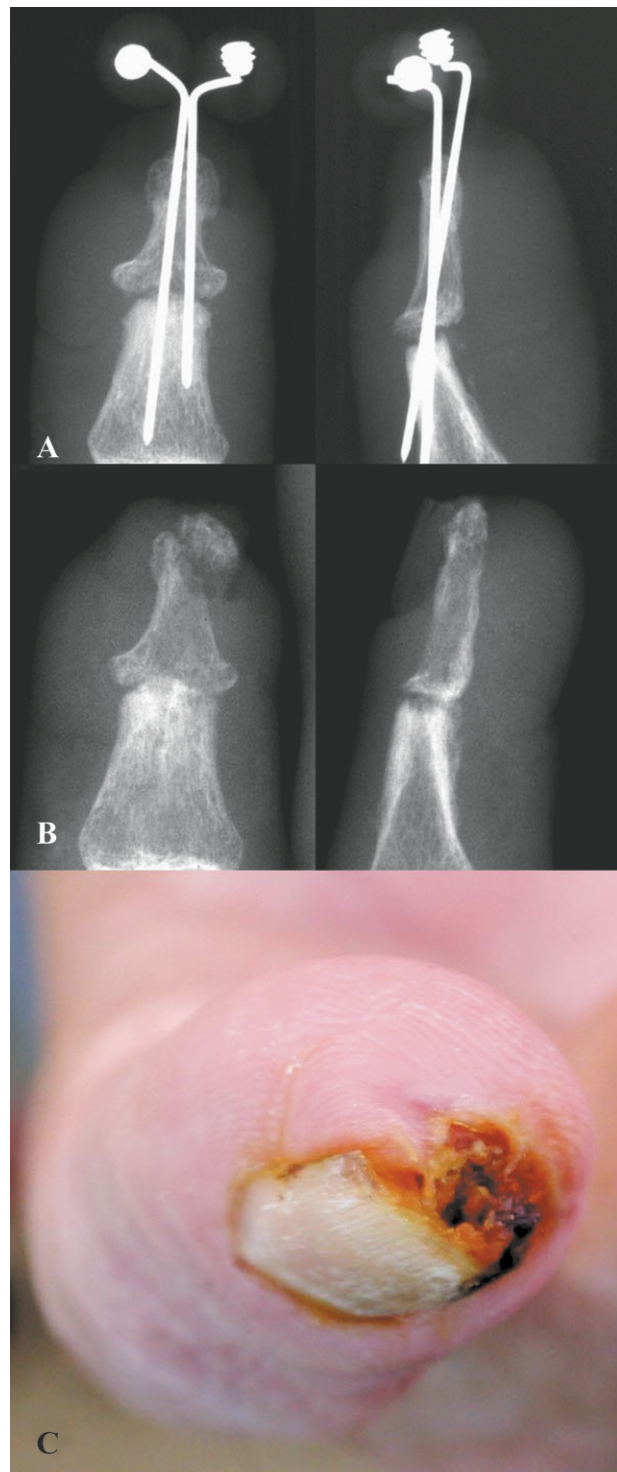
Radiographs showing (A) Kirschner wires and Jurgan Pin Balls in place soon after the injury, (B) osteomyelitis of the phalangeal tuft, and (C) Exposed phalangeal tuft.
